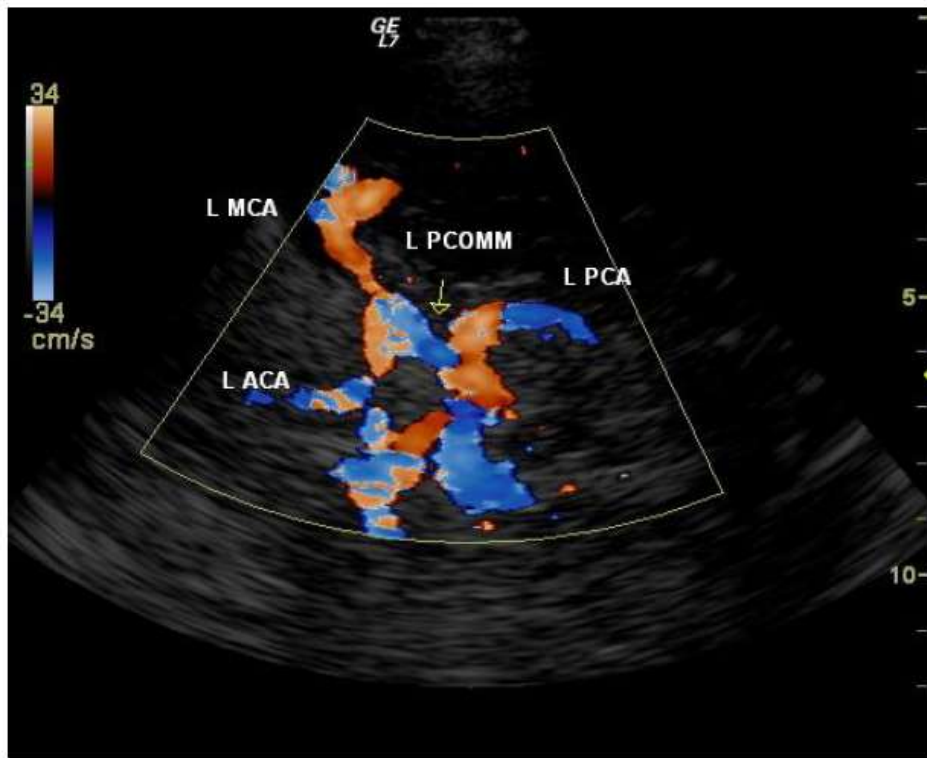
Circle of Willis, left temporal window, colour-coded Doppler mode.
